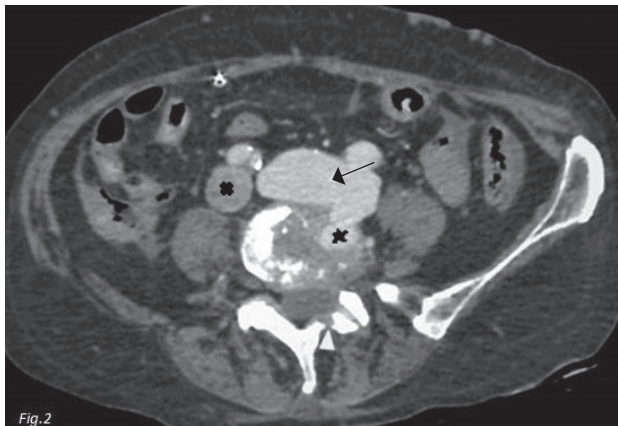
Abdominal CT, arterial phase, at the L4-L5 level exhibiting simultaneous enhancement of left common iliac artery and vein, marked dilatation of left common iliac vein, loss of adipose tissue between them (arrow) and non-enhancement of right common iliac vein (x), all of which are findings of left common iliac AVF. Note the presence of contrast agent in the intervertebral space (asterisk) and the left hemilaminectomy in the same line with the iliac communication (white arrowhead).
